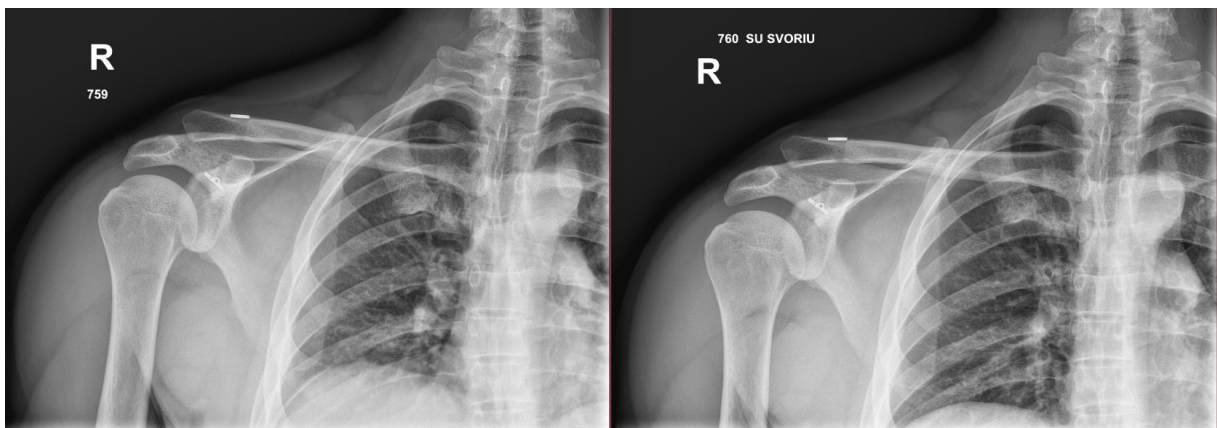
07.12.2021 X-Ray Right Shoulder
